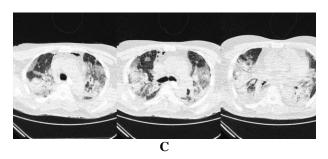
the first unenhanced chest CT scan after admission with mainly peripheral bilateral patchy ground-glass opacities and consolidations
